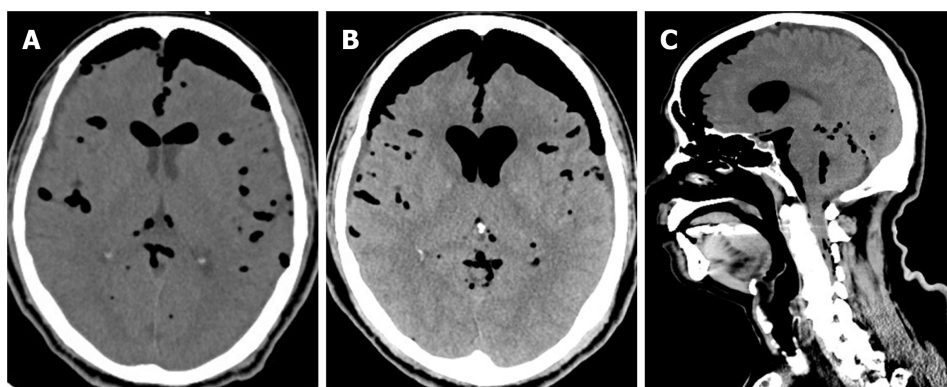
Computed tomography scans of the patient's brain showing tension pneumocephalus. A: Non-contrast views of preoperative brain computed tomography images; B-C: Images of axial (B) and sagittal view (C) show progressive tension pneumocephalus, pneumoventricle, and air leak in the spinal canal.
